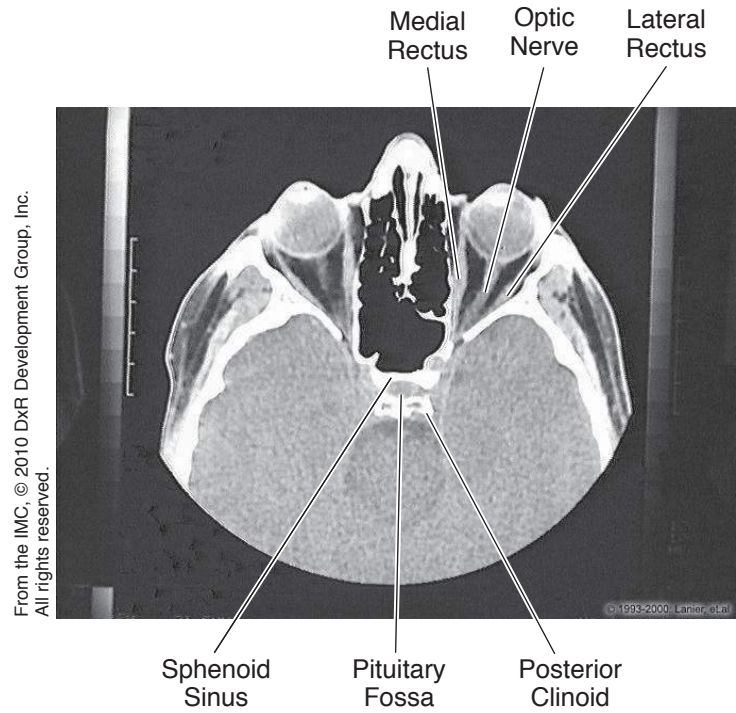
Head and Neck: CT, Orbit
